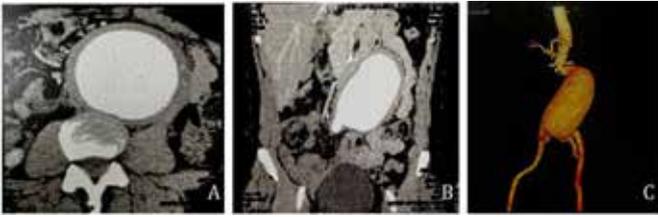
Computed Tomography Angiography of the abdomen – A: axial section showing an Abdominal Aortic Aneurysm measuring 9.1 cm in its largest diameter, with thickened walls; B: coronal section showing an Abdominal Aortic Aneurysm with an extension of 14.1 cm; C: 3D Reconstruction of Infrarenal Abdominal Aortic Aneurysm.
